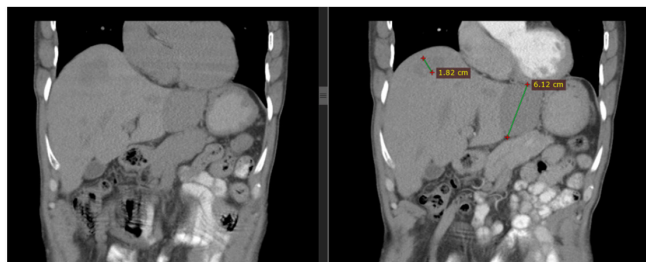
Left image: Native CT scan showing hypodense lesions on the left and right liver lobes. Right image: After intravenous contrast application, there is no pathological contrast concentration in the arterial phase.
